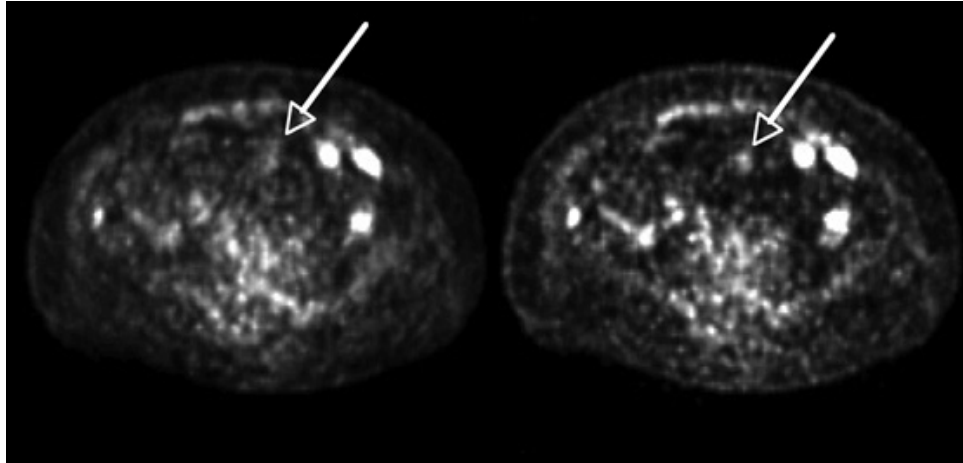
A patient with colon cancer, after injection of 555-MBq of FDG and scan for 3 min/bed position following a 60-min uptake period, Left: non-TOF image, Right: TOF image. In TOF image cancerous lesion can be clearly discerned. Image reprinted from Joel Karp, 2008 [1].
